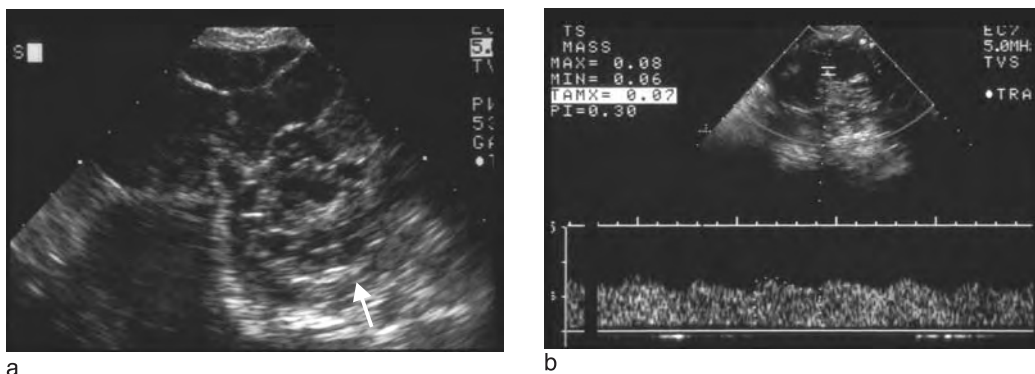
Mucinous cystadenocarcinoma, diameter 15 cm. (a) Transabdominal scan shows cystic mass with multiple septa, reflective material in fluid and solid area (arrowed). (b) Transvaginal Doppler examination shows spectral trace with high diastolic flow, PI = 0.30.
